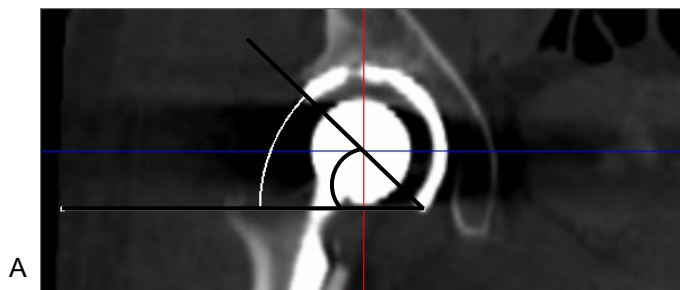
Measurement of (A) radiographic inclination on the tomographic coronal plane, and (B) anatomical anteversion on the tomographic axial plane.
